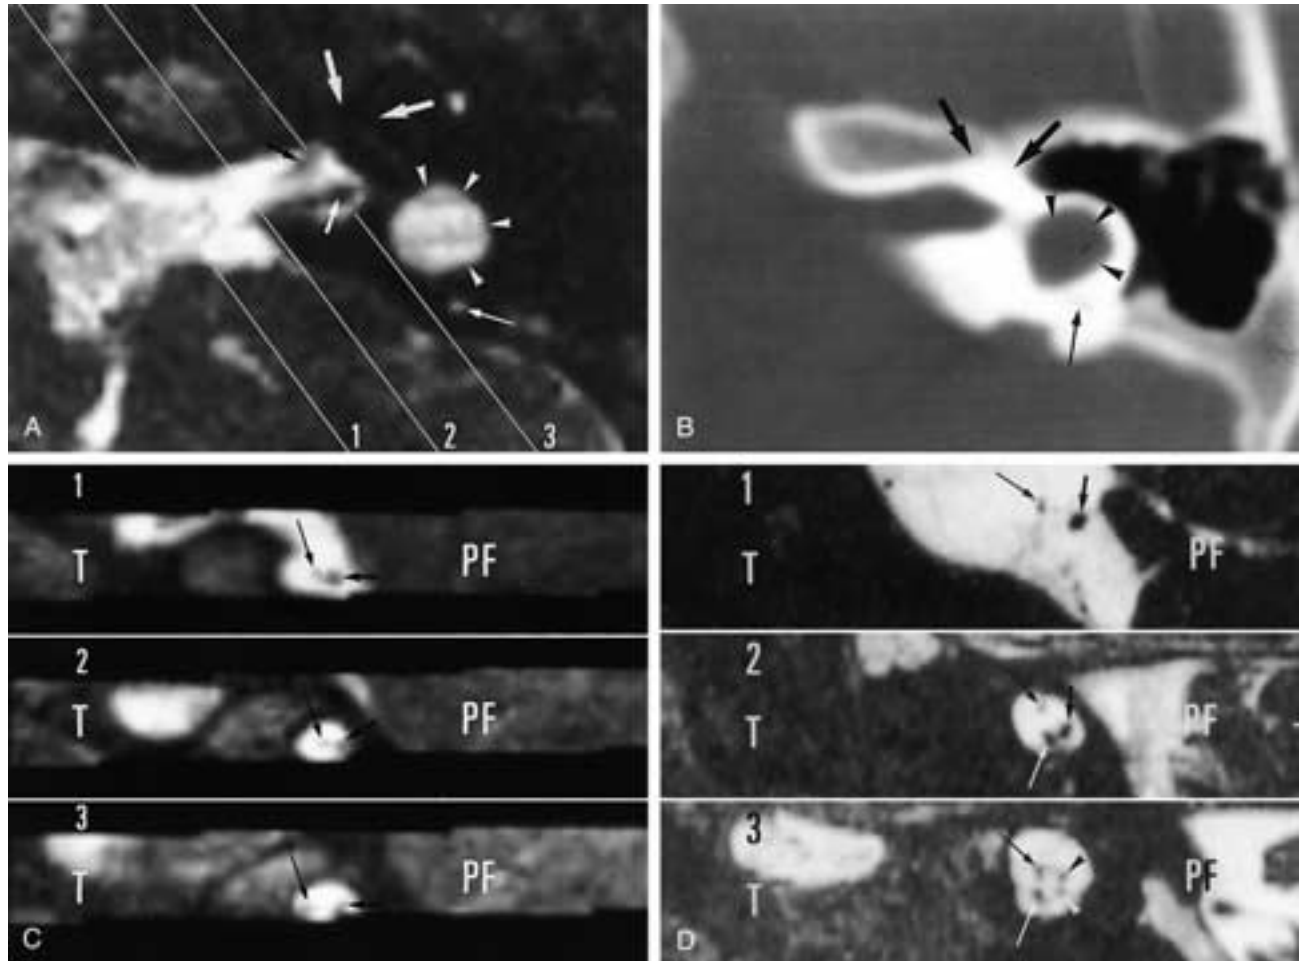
Common cavity-type cochlear-vestibular malformation with associated aplasia of the cochlear branch of the VCN, Type 2A malformation. A, Axial 0.7 mm thick gradient-echo image through the left inner ear. A fluid-filled cavity (white arrowheads) is seen posterior and lateral to the fundus of the IAC. No fluid can be seen at the site where the cochlea is expected to be located (large white arrows). A normal posterior semicircular duct can be recognized (long white arrow). Only two nerves are seen passing through the IAC—the facial nerve (small black arrow) and a common VCN or vestibular nerve (small white arrow). B, Axial CT image through the left inner ear. Confirmation of the absence of a separate cochlear structure (black arrows) and the presence of a common cavity (black arrowheads) and normal posterior semicircular canal (long black arrow). C, Gradient-echo images, oblique sagittal reconstructions of the left inner ear at the level of the cerebellopontine angle (1), and porus (2) and fundus (3) of the IAC; see the levels on A. A smaller facial nerve (long black arrows) and a thicker common, or rudimentary, VCN (small black arrows) can be followed from the cerebellopontine angle (1) to the fundus of the IAC (3). A separate cochlear branch normally situated in the anterior and inferior parts of the IAC cannot be recognized, and there is no bifurcation into a superior and inferior vestibular branch. D, Gradient-echo images, oblique sagittal reconstructions of a normal inner ear for comparison. The facial nerve again can be depicted as a smaller nerve (long black arrows). The common VCN (small black arrows) gives off its cochlear branch (long white arrows) when it reaches the porus (2) and divides into a superior (black arrowhead) and inferior (white arrowhead) vestibular branch deeper in the IAC (3). PF, posterior fossa; T, temporal lobe. A cochlear implant was installed, and the results were moderate to satisfactory. This case proves that cochlear implantation can be of benefit once a fluid-filled inner ear cavity is found and the presence of a nerve, which is not the facial nerve, can be demonstrated.
